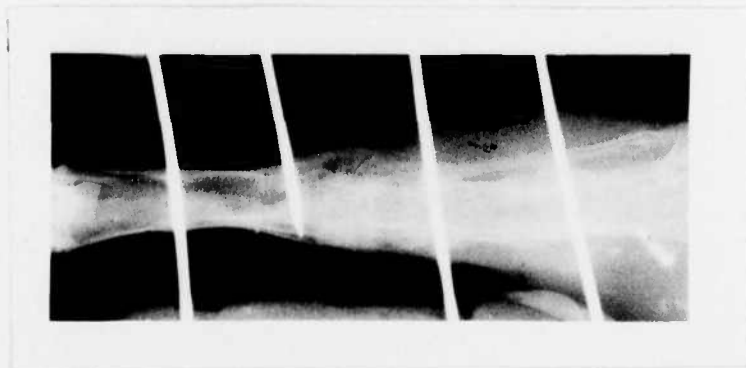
Radiographs showing a Nonunion Lesion and a 50/50 Ratio of Ceramic and Bone Implant at 11 weeks post surgery (a), and 5 weeks (b) and 13 weeks (c) post implantation.
